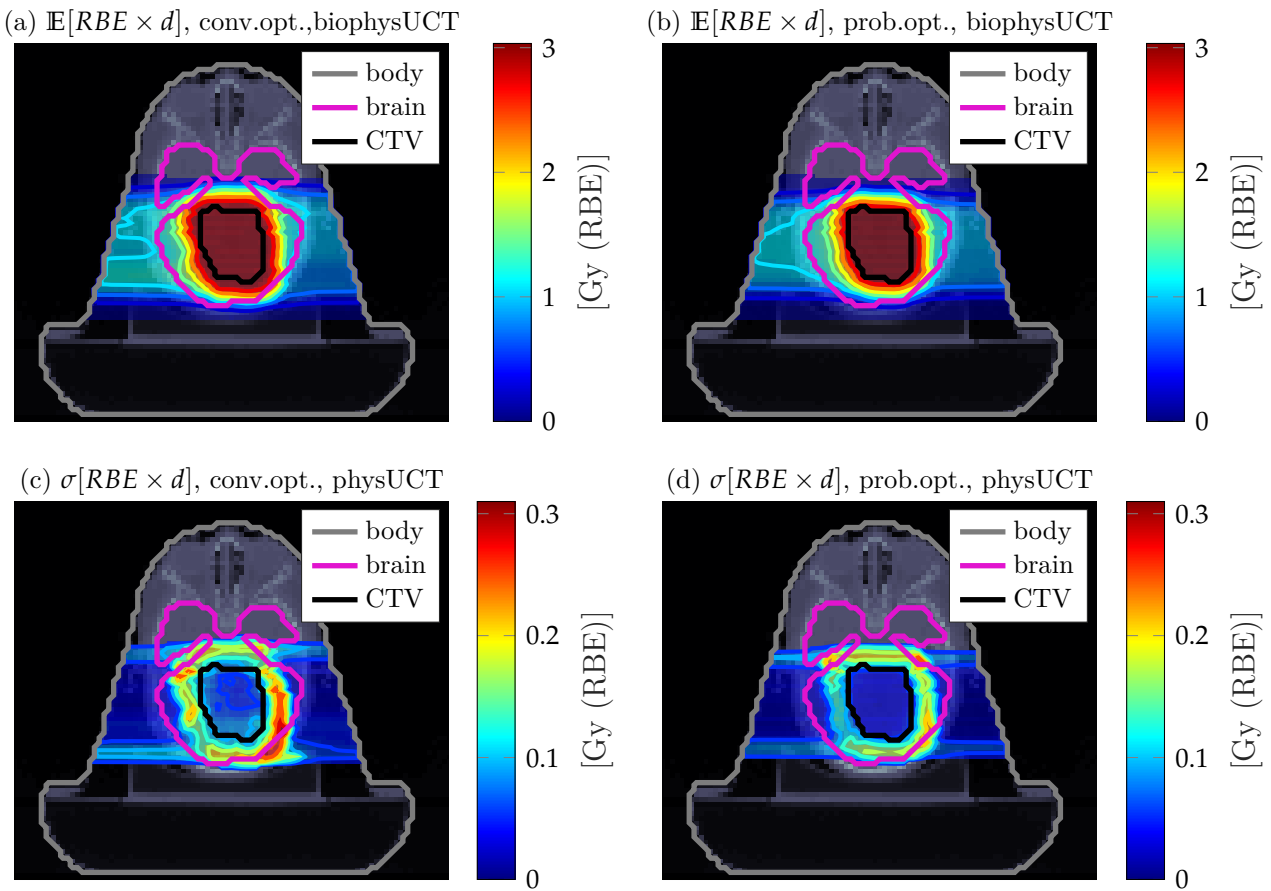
Transversal CT image of a cranial patient with transparent dose colorwash, solid contours and solid isodose lines representing quantified treatment plan uncertainties on the basis of conventional optimization in (a) and (c) as well as of probabilistic optimization in (b) and (d).
